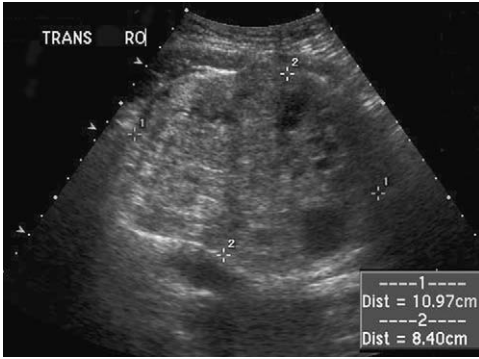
Ovarian torsion in a patient with acute pelvic pain 2 weeks postpartum. Sonography showed a markedly enlarged right ovary with no flow on color Doppler (not shown).
